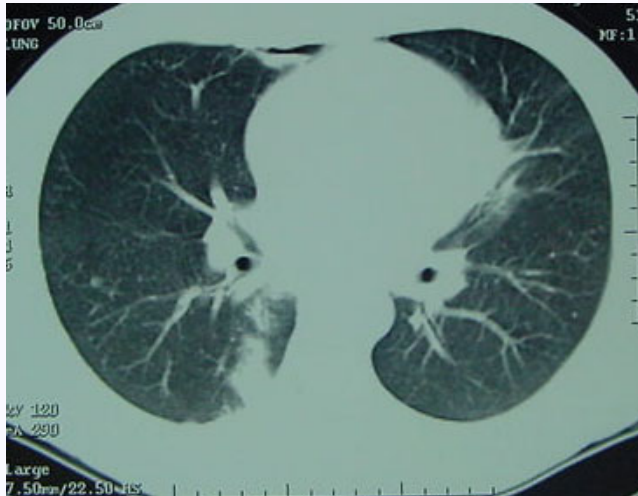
CT chest with gunshot tract seen in right lung base.
